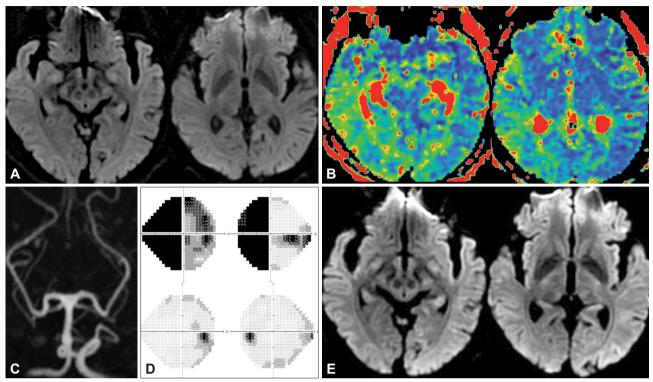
Brain MRI and visual field examination of the patient. A: Initial brain diffusion-weighted MRI shows no acute ischemic lesion. B: The mean transit time is delayed in the right parieto-occipital lobe in perfusion-weighted MRI. C: Magnetic resonance angiography shows that there is no significant steno-occlusive lesion in the posterior cerebral artery. D: A left homonymous field defect is noted in the initial visual field examination (upper panel), and this is normalized after steroid therapy (lower panel). E: Follow-up MRI shows no ischemic lesions. MRI: magnetic resonance imaging.
